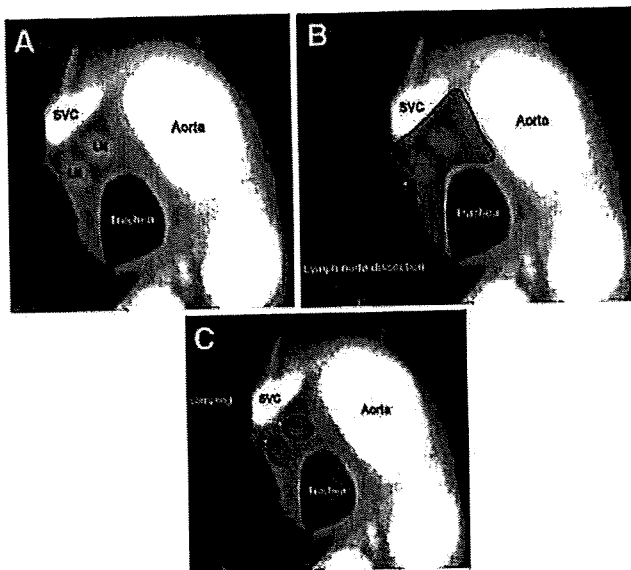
The differences in the extent of nodal dissection and sampling demonstrated on computed tomography (CT) images. *A*, Pretracheal lymph nodes and surrounding fatty tissue in the superior mediastinum. *B*, The extent of lymph node dissection. *C*, The extent of lymph node sampling. SVC, superior vena cava; LN, pretracheal lymph node.
